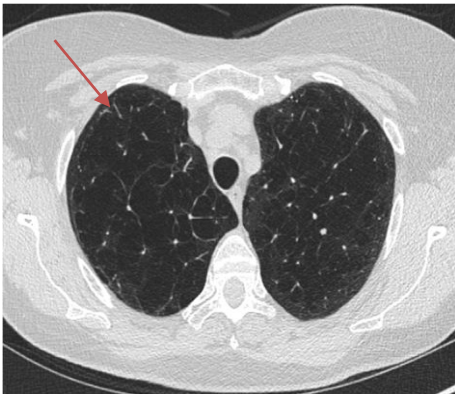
CT scan of patient with centrilobular emphysema (red arrow). Scan from study 1.
